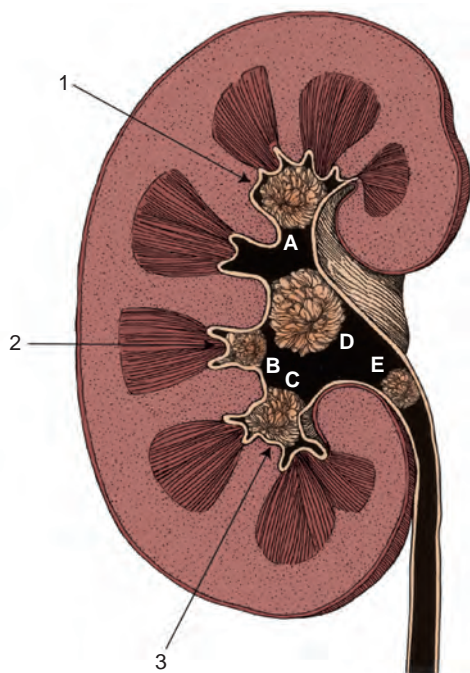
Nephrostomy tract puncture site. Position of the nephrostomy is imperative for successful percutaneous resection of transitional cell carcinoma of the renal collecting system and upper ureter and requires careful preoperative evaluation of radiographs for tumor location. Tumors in peripheral calyces (A to C) are best approached by direct puncture as far distally in the calyx as possible. Tumors in the renal pelvis (D) and upper ureter (E) are best approached by puncture to an upper (1) or middle (2) calyx, which allows the scope to be maneuvered in the renal pelvis and down the ureter. Tumors in the lower calyx are approached by lower calyx puncture (3).
